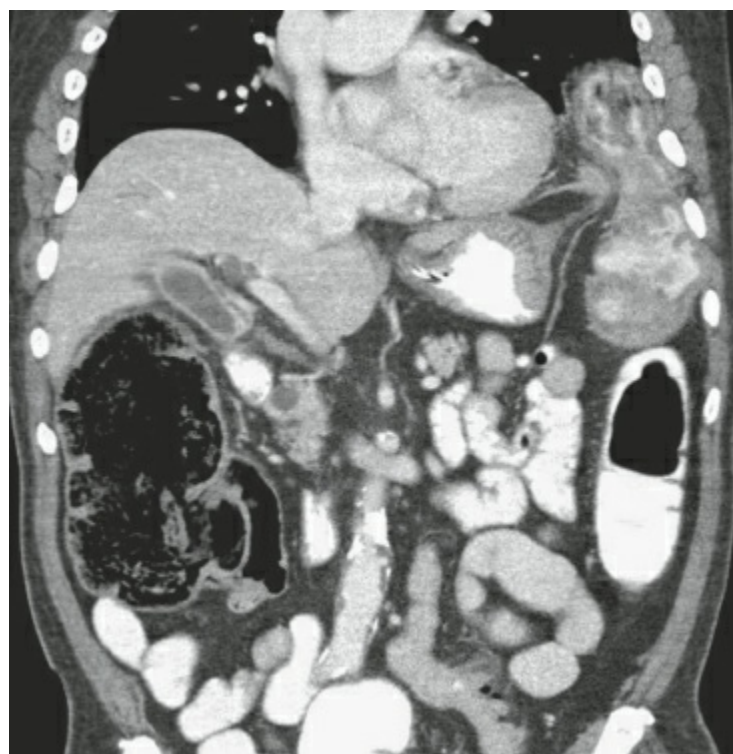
CT demonstrating left blunt diaphragmatic injury with herniating gastrointestinal tract contents.
